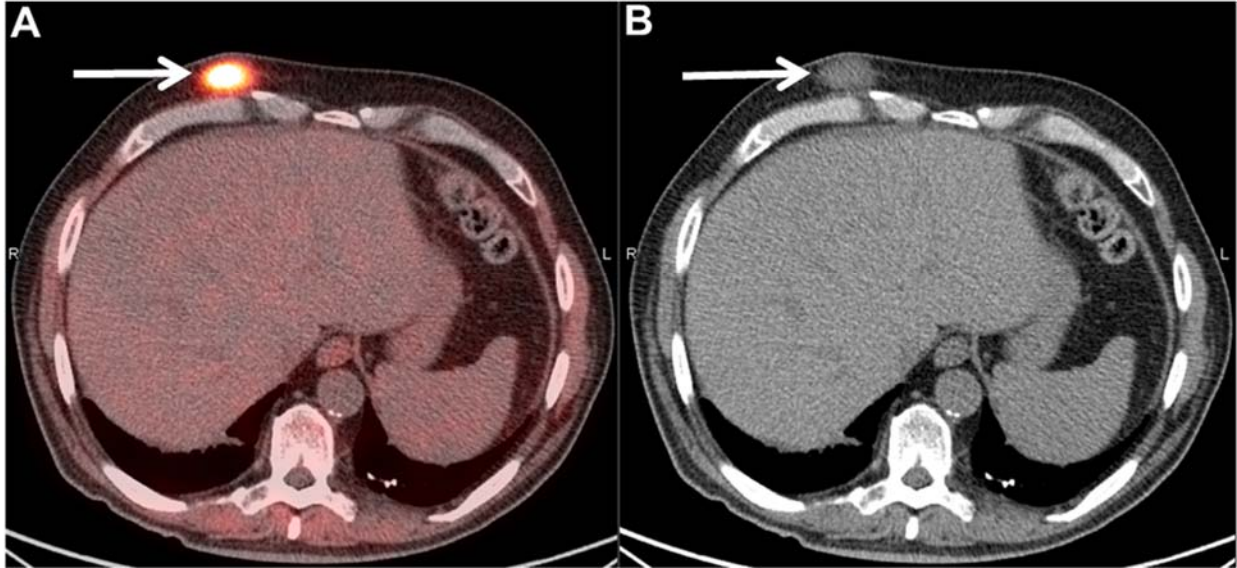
Restaging 18F-FDG PET/CT (arrows in A & B) images showed right anterior chest wall subcutaneous FDG-avid nodule with SUVmax 10.3. Excisional biopsy confirmed cutaneous LYG, WHO grade 1.
